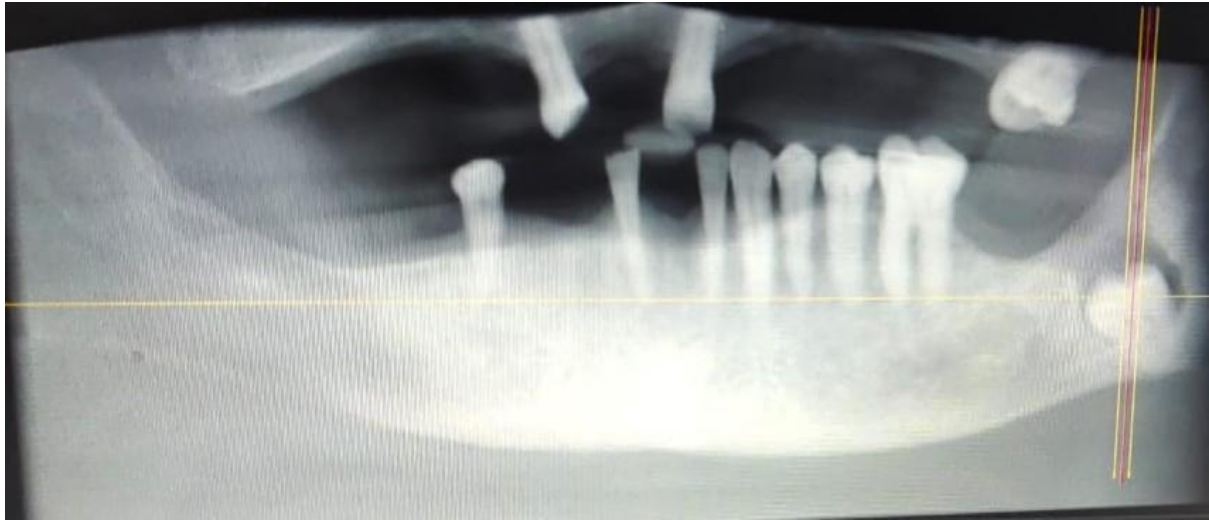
Pre operative radiograph reveals a well defined radiolucency surrounding impacted 38
